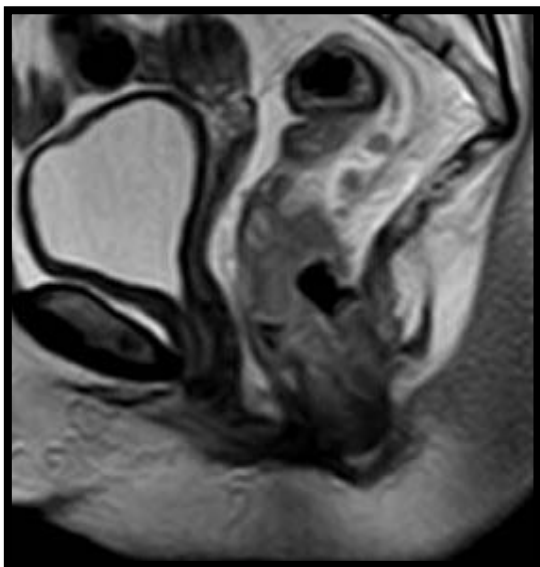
51 years old female with ano-rectal cancer. Sagittal T2-weighted imaging showing lower rectal neoplastic mass with infiltration of the anal canal.
